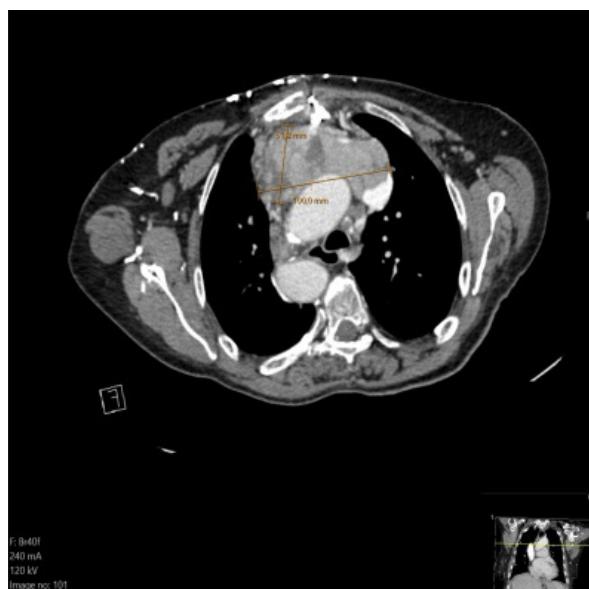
Contrast-enhanced CT of the chest showing a large anterior mediastinal mass infiltrating the left brachiocephalic vein.
